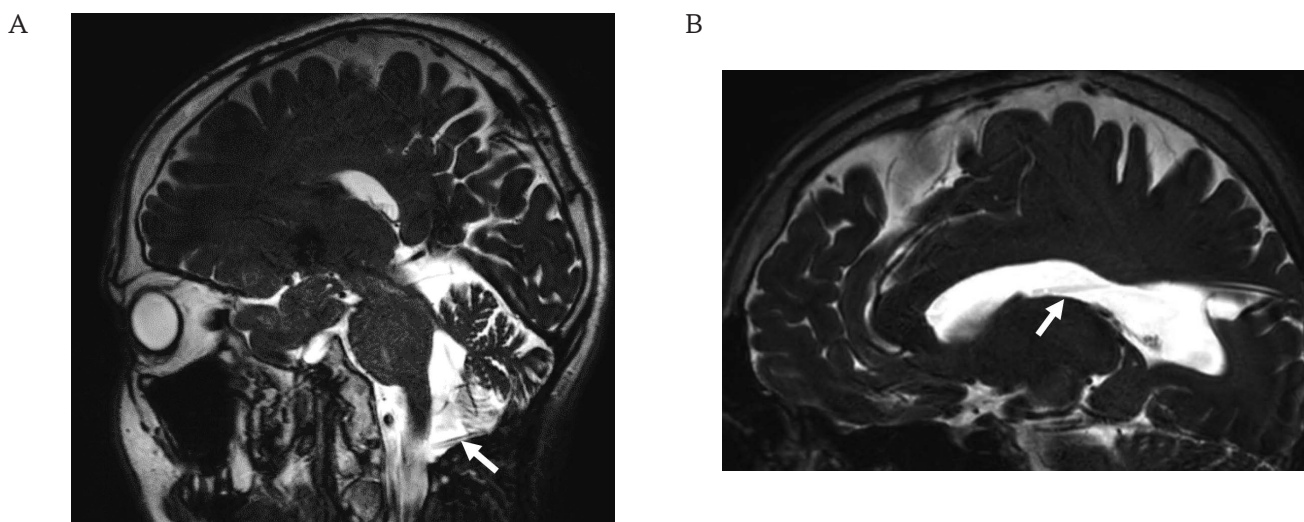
Magnetic resonance imaging of the brain performed 1 month after surgery (October 29, 2015).
